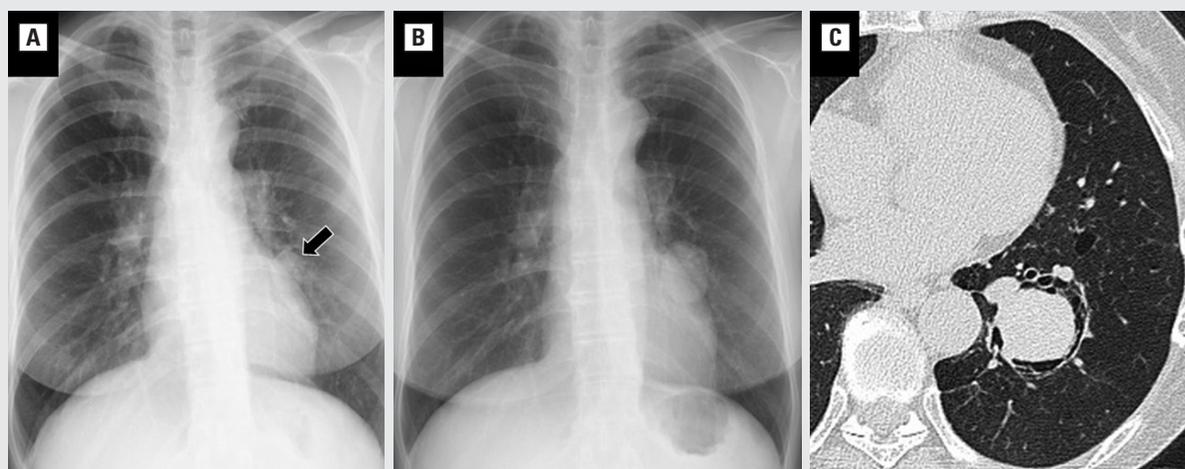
A nodule in the left lung (arrow) in plain chest radiograph taken 7 years ago (A), and that taken at the first visit to our hospital (B). The nodule in chest computed tomography taken 18 months after the first visit (C)
